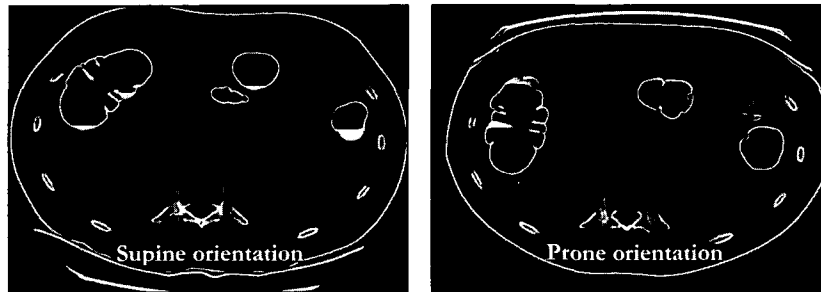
CT images of the colon. Air is black, tissue is grey and intraluminal remains are white if tagged or tissue equivalent if not tagged.
